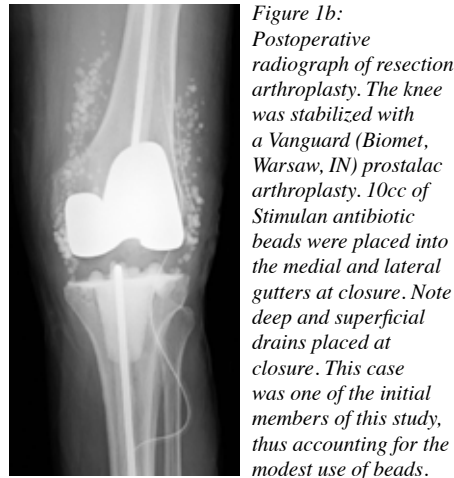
Postoperative radiograph of resection arthroplasty. The knee was stabilized with a Vanguard (Biomet, Warsaw, IN) prostatic arthroplasty. 10cc of Stimulan antibiotic beads were placed into the medial and lateral gutters at closure. Note deep and superficial drains placed at closure. This case was one of the initial members of this study, thus accounting for the modest use of beads.
